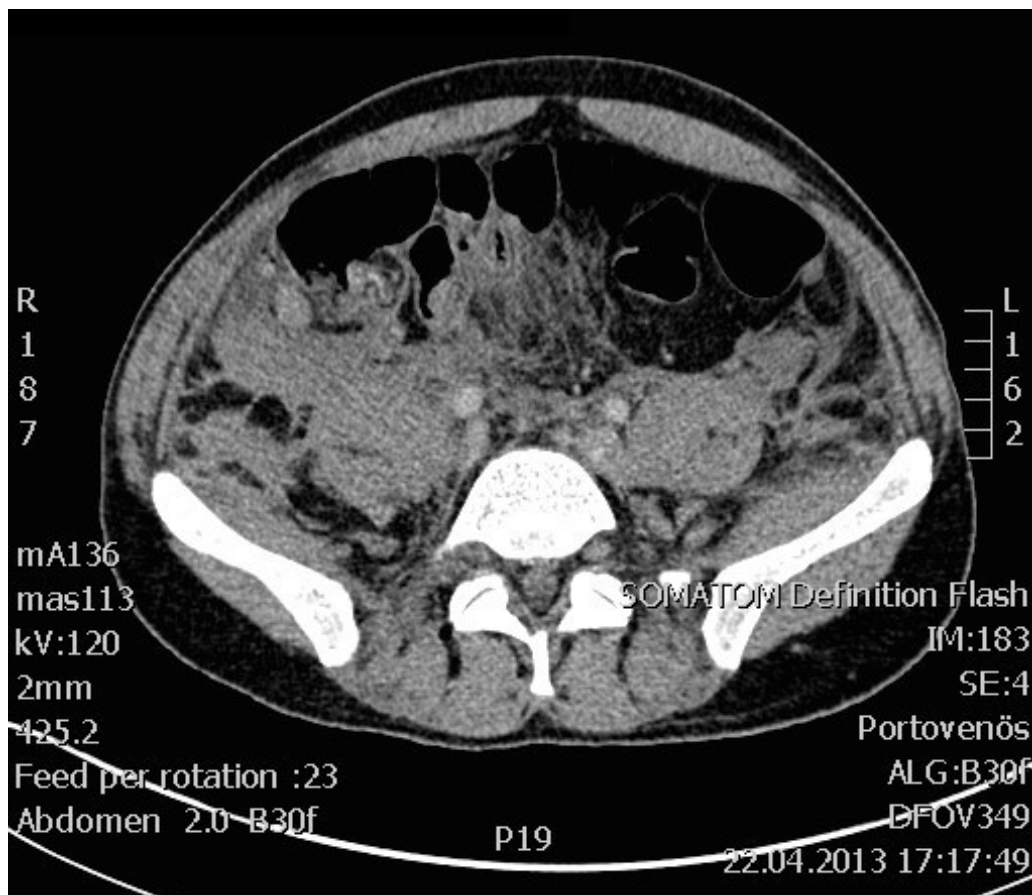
CT scans at Stage IV of disease. Above: free liquid in the pelvis. Below: multiple lymph node metastasis.
